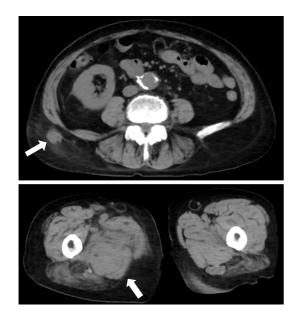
A computed tomography scan showed subcutaneous hematoma in the right hip (a) and intramuscular hematoma in the right thigh (b).
